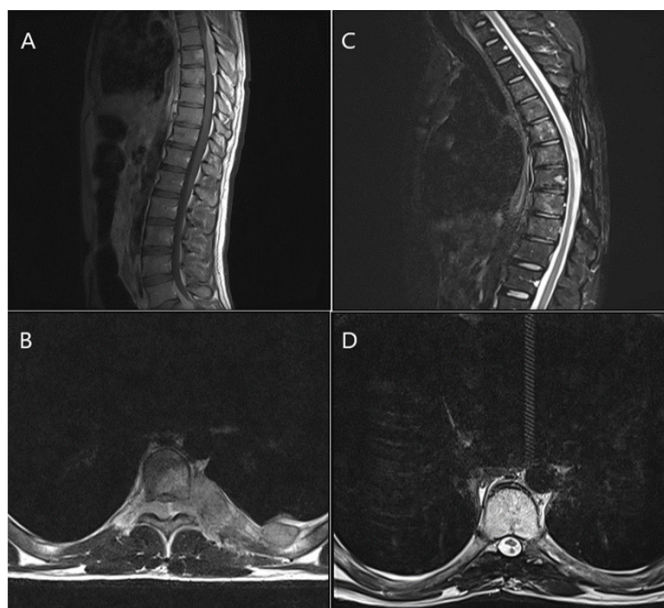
Magnetic resonance images at the initial visit (A, B) and post-treatment visit (C, D). Sagittal (A) plane at T6–8 and axial (B) planes at T7 show abnormal lesion located intradural extramedullary space of the thoracic spinal canal. Sagittal (C) and axial (D) planes had been shown complete disappearance of post-treatment with chemotherapy
